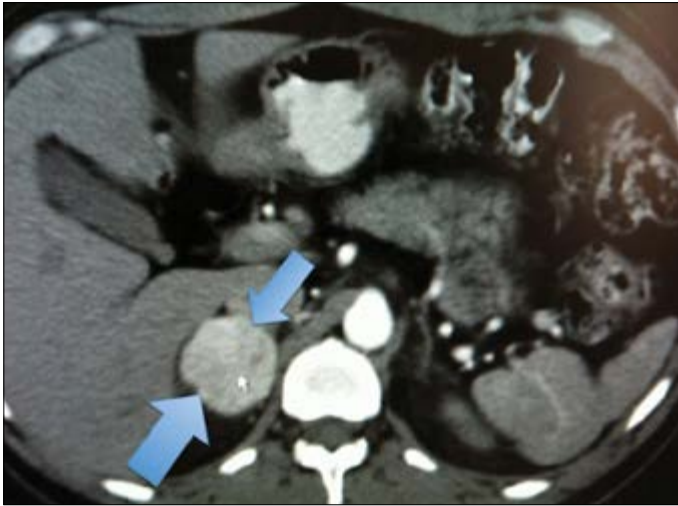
Appearance of a 5 x 4 cm right adrenal mass with contrast enhancement on abdominal computed tomography (arrow)
